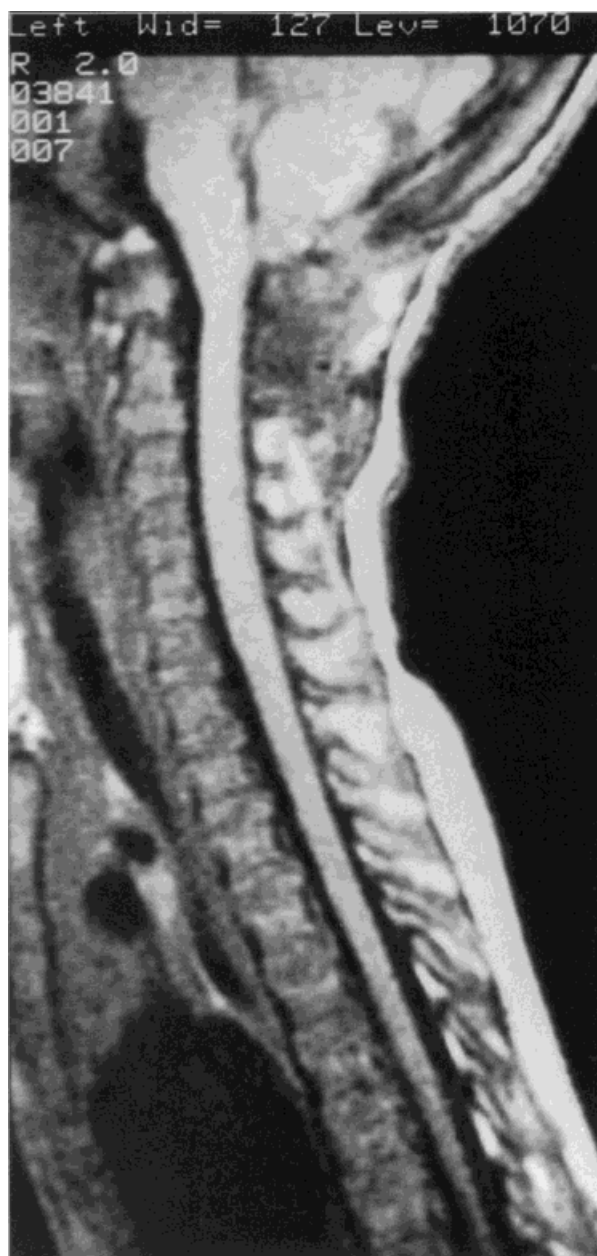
Same patient as in Figure 4, 2 months later. The postoperative MRI study shows the surgically induced posterior ossification defects producing increased space for the cord.
